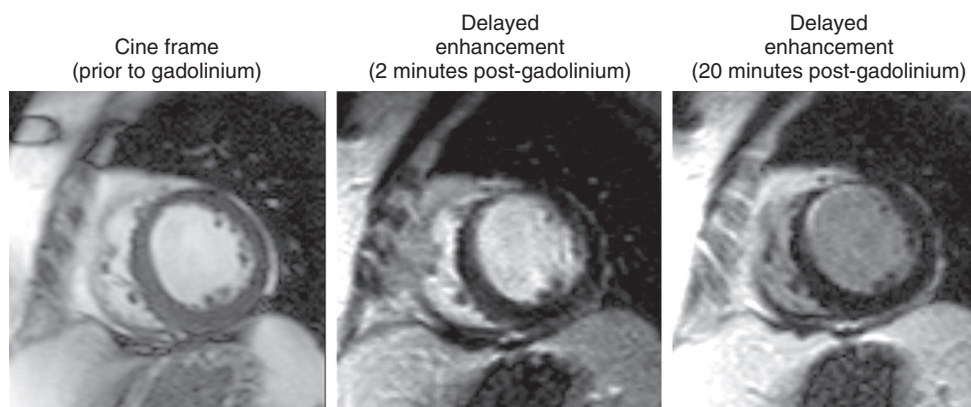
e11 Short-axis view of a patient with an anterior wall myocardial infarction. Diastolic still frame from a cine series is compared with the delayed enhancement images obtained early and late after gadolinium administration. Note that it is difficult to differentiate the bright left ventricular cavity from the subendocardial infarction in the early (2 mins) delayed enhancement image. The cine frame, by showing the diastolic wall thickness of the anterior wall, provides evidence that there is subendocardial hyperenhancement in the anterior wall that is difficult to see on the early delayed enhancement image. The late (20 mins) delayed-enhancement cardiac magnetic resonance image confirms that there is subendocardial hyperenhancement in the anterior wall. (From Kim RJ, Shah DJ, Judd RM: How we perform delayed enhancement imaging. *J Cardiovasc Magn Reson* 5:505–514, 2003.)
